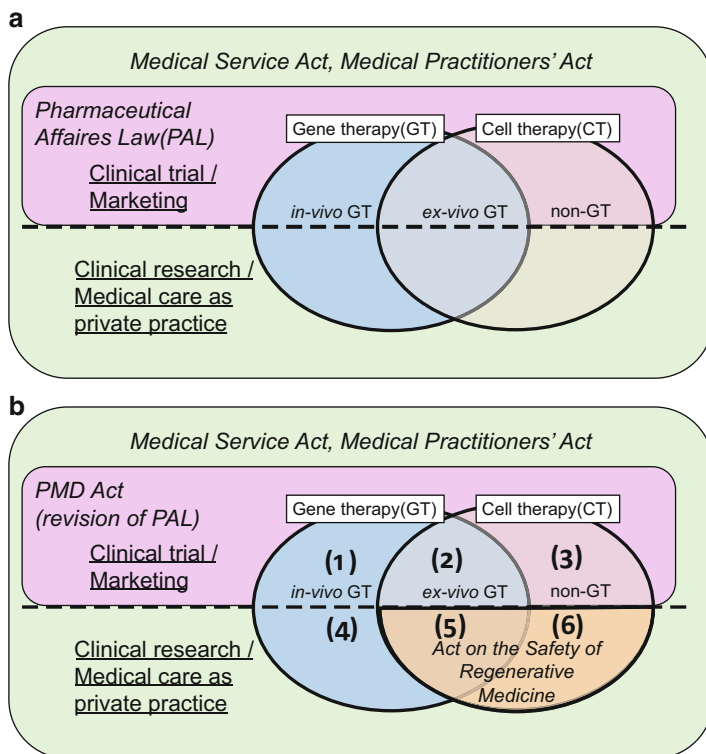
Legislation for GT and CT. Legislation for GT and CT changed, (a) until November 24, 2014, (b) after November 25, 2014
